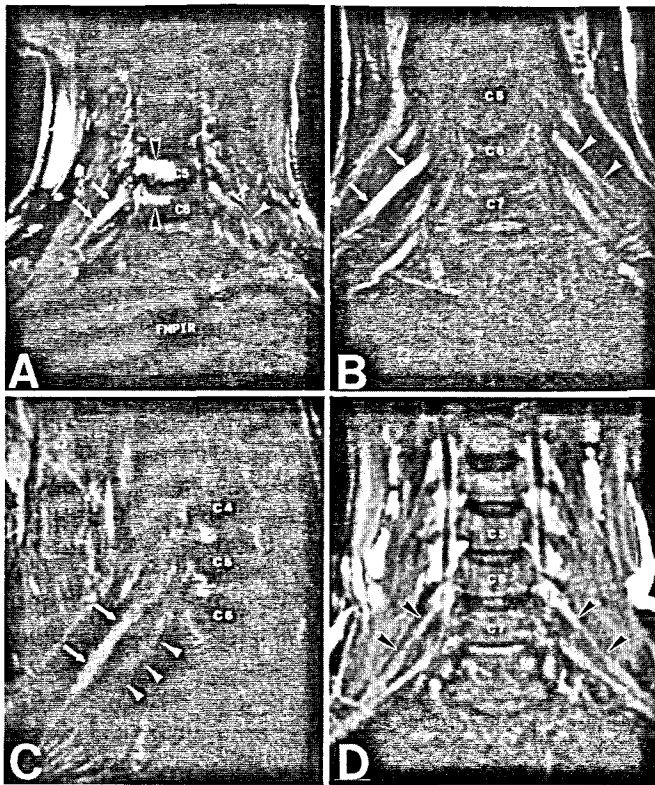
A, coronal FMPIR image from Patient 1. Note the markedly higher signal in the right C6 spinal nerve (arrows) when compared with the left (white arrowheads). Also note the degenerative reactive marrow changes in the C5 and C6 vertebral bodies (black arrowheads). B, coronal FMPIR image from Patient 2. Again note the higher signal in the right C6 nerve (arrows) when compared with the asymptomatic left C6 spinal nerve (arrowheads). C, coronal T2-weighted fast spin echo image from Patient 3. The right spinal nerves are visible in this image, which shows higher signal in the C5 nerve (arrows), corresponding to the EMG results, than in the adjacent C6 nerve (arrowheads). D, coronal FMPIR from an asymptomatic volunteer (Patient 4). No differences in signal intensity are identified when comparing the right and left C6 spinal nerves (arrowheads).
